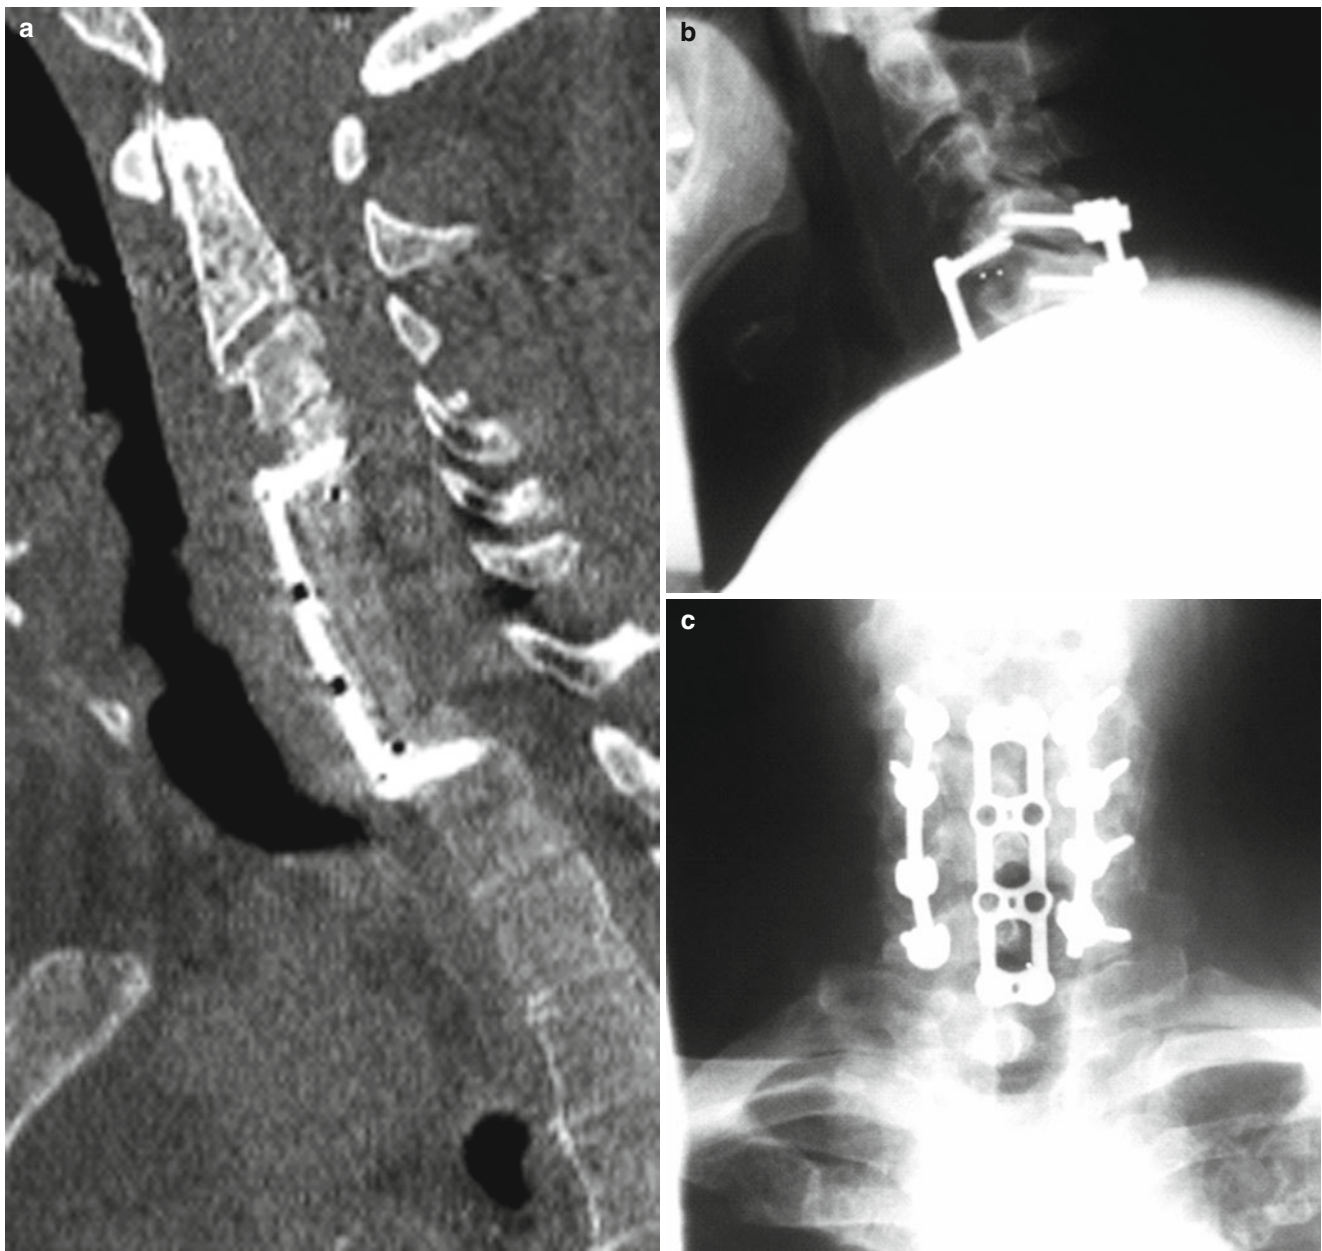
(a) Final postoperative CT; (b, c) final postoperative anterior-posterior and lateral radiographs
